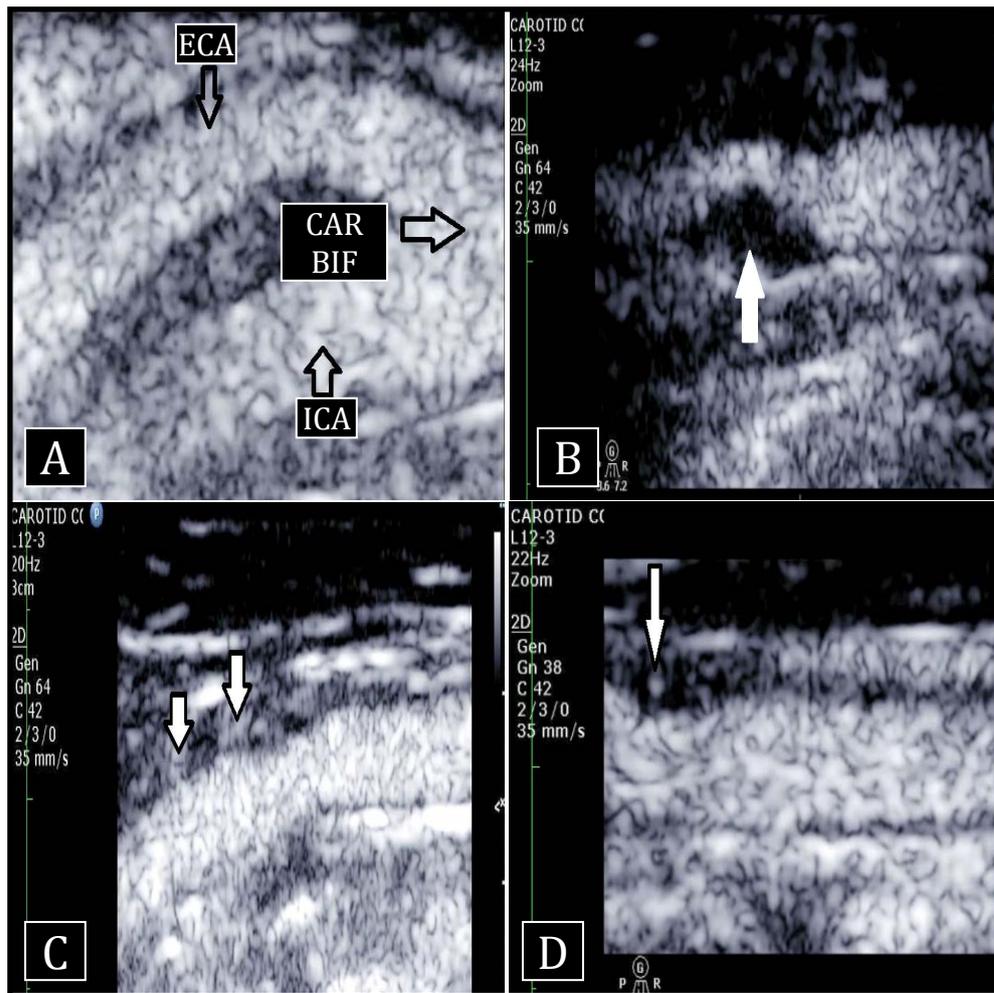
Contrast-enhanced Carotid Ultrasound.
